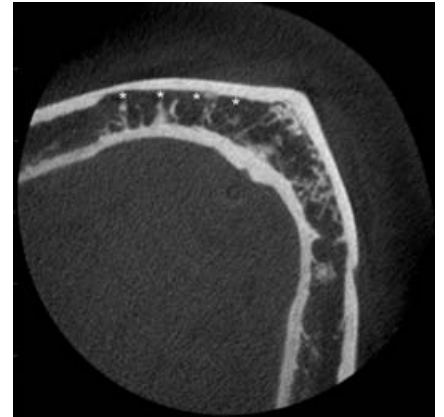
Axial CBCT slice
